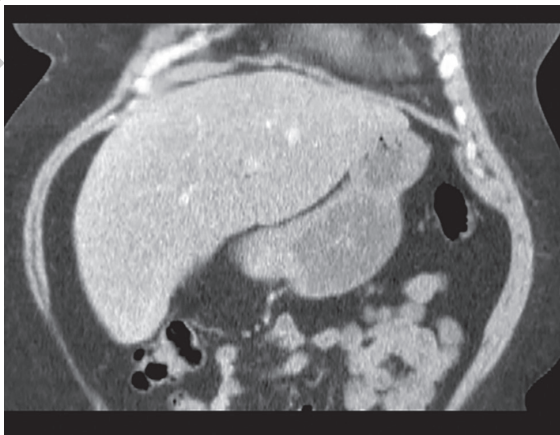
CT scan of the above coronal view.
